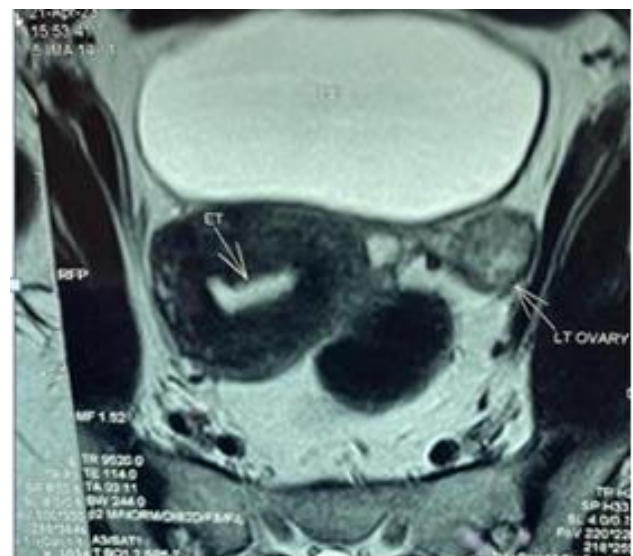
MRI pelvis showing shows altered signal intensity of left ovary.
